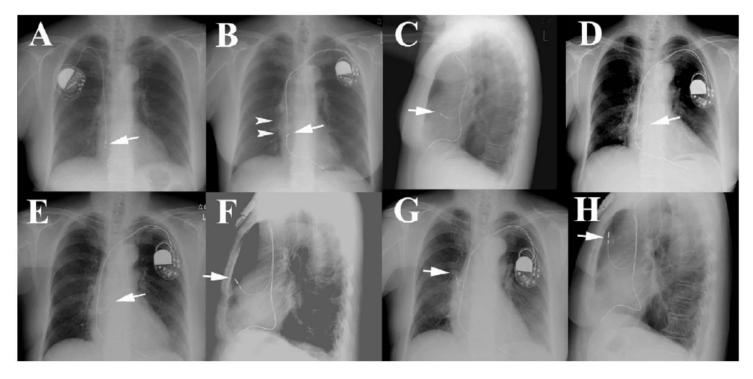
Chest X-rays. Compared to the image before the replacement of pacemaker (A), the image 1 week after the replacement (B) showed only a focal protrusion from the right side of cardiac silhouette (arrowheads) and the lateral image (C) did not show any abnormalities. The image 2 years later had no serial change (D), however 3 years and 9 months later, a lateral view (F) clearly showed atrial lead protrusion, while the lead changed to be tip-tilted on the frontal view (E). One year later, both of frontal (G) and lateral views (H) demonstrated the progression of atrial lead protrusion. The arrows indicate the distal tip of atrial lead.
